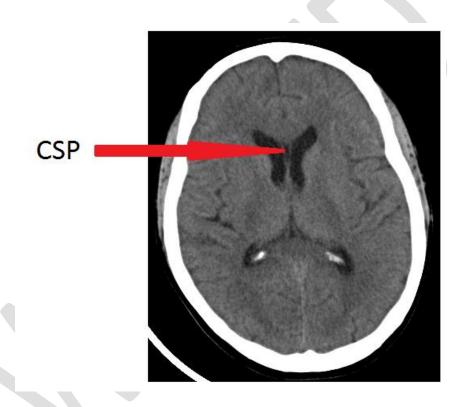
Small CSP (axial slice of a pre-contrast CT scan of the brain at the level of the frontal horns of the lateral ventricles)
